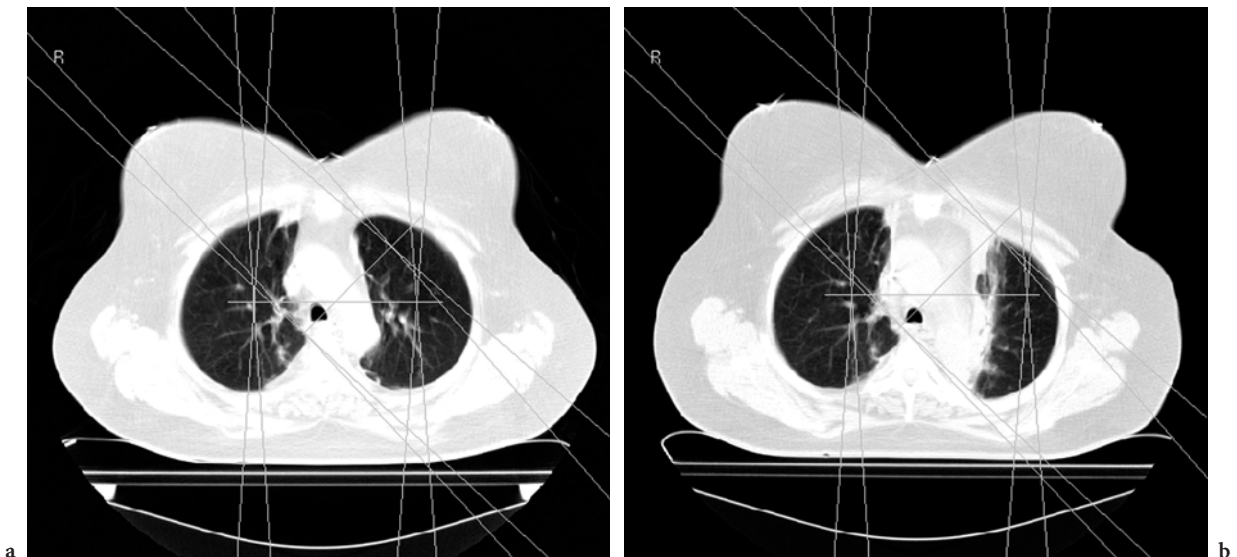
The pre- and 12-month post-RT CT images from a patient irradiated for lung cancer are shown in (a) and (b), respectively. The beam paths are shown (anterior, posterior, oblique). There is increased CT density in the irradiated medial left lung following RT
